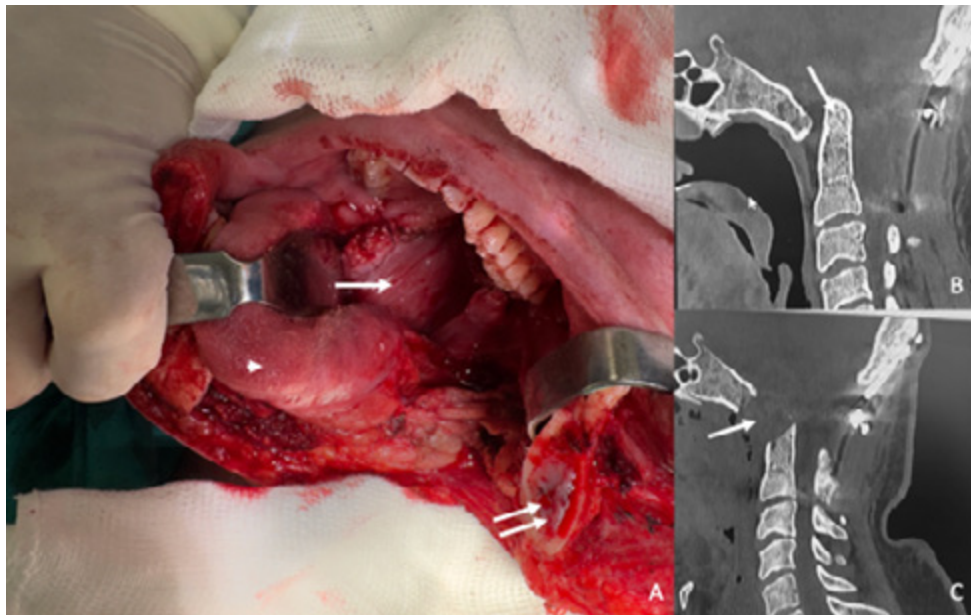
A 32-year-old male patient with Chiari syndrome type 1 and invagination had previously undergone occipitocervical stabilization and posterior fossa decompression due to Chiari. Because significant motor deficits and respiratory failure persisted, an odontoidectomy and clivectomy of the inferior clivus were performed. Because the basilar impression was significant (angle difficulty with a purely endoscopic approach) and the patient's mouth opening was insufficient for a purely transoral approach, a transoral surgical approach with mandibulectomy was performed to adequately expose the surgical field, primarily due to the need for sufficient angulation for drilling the inferior clivus before resecting the invaginated odontoid process. The use of a neuronavigator was crucial in the surgical stages, and the patient recovered from the deficits and was weaned from the ventilator. A. Intraoperative image of the transoral approach with mandibulectomy (double arrow), providing a wide field of view of the posterior pharynx (arrow), after lateral displacement of the tongue (arrowhead). B. Preoperative sagittal CT scan showing invagination of the odontoid process (arrow). C. Postoperative CT scan showing removal of the odontoid process and inferior clivus (arrow).
